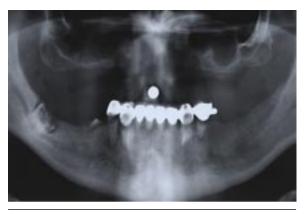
Preoperative x-ray of patient's dental condition.
